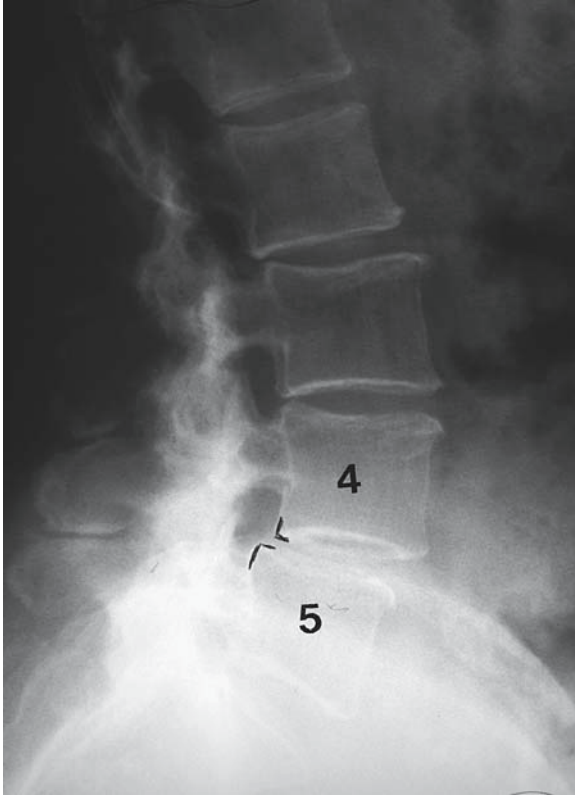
Lateral radiograph demonstrates a grade 1 degenerative spondylolisthesis at L4–L5.
